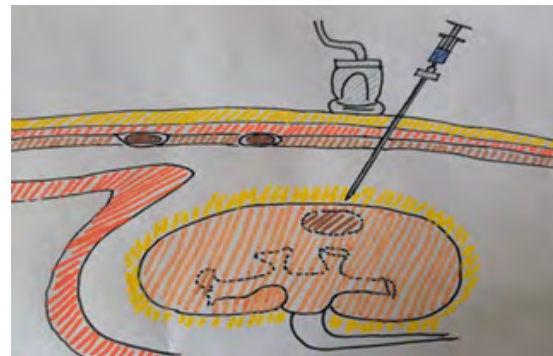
Under ultrasound guidance, the tip of the puncture needle reached the surface of the renal fat layer of the completely endogenous renal tumor. The marking point was the central position of the renal surface projection of a completely endogenous renal tumor. The black arrow points to the renal tumor.
